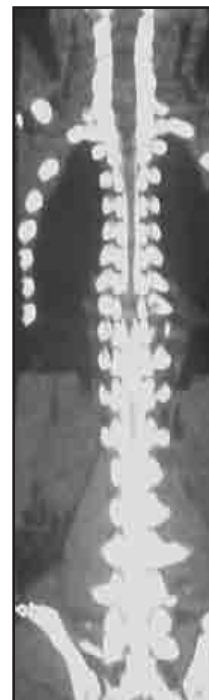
Coronal CT scan of the entire spine clearly showing the paravertebral abscess in the thoracic region
